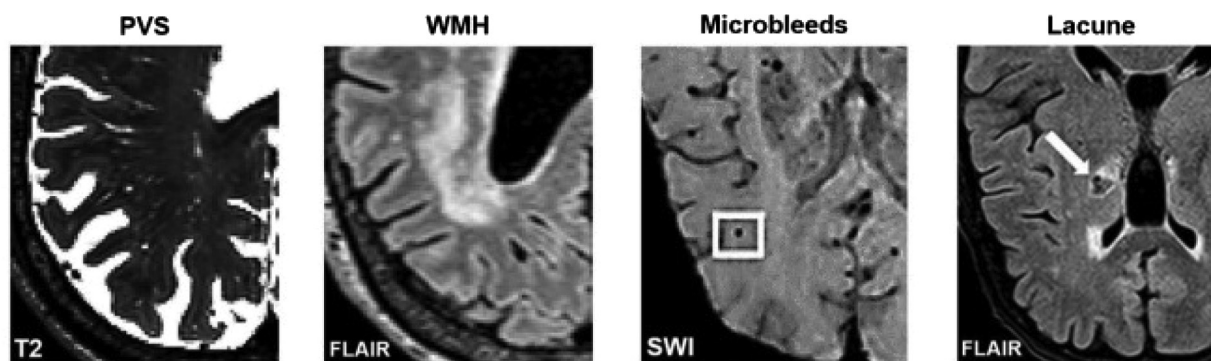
Axial slices of MRI-visible brain lesions, including PVS, white matter hyperintensities, microbleeds, and lacunes.
